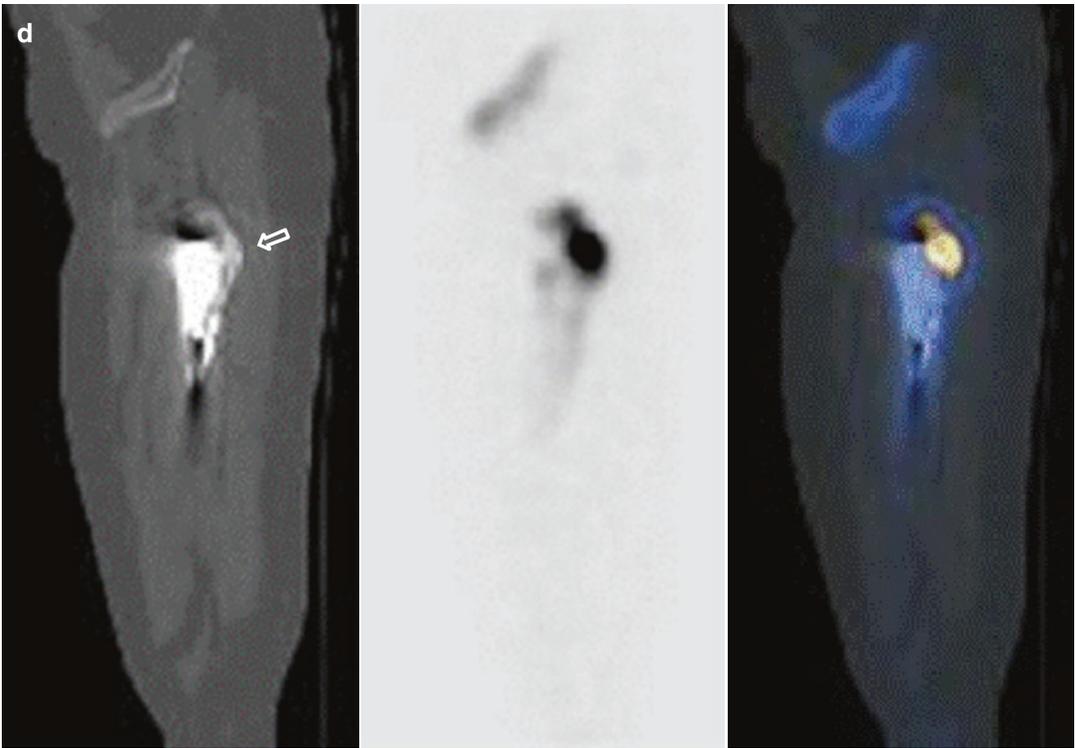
In this 63 year old female patient with history of right total hip replacement, whole-body blood pool (a) and delayed images (b) demonstrate hyperemia and increased osteoblastic activity posterolateral to the right trochanteric region. Selected coronal and sagittal SPECT/
